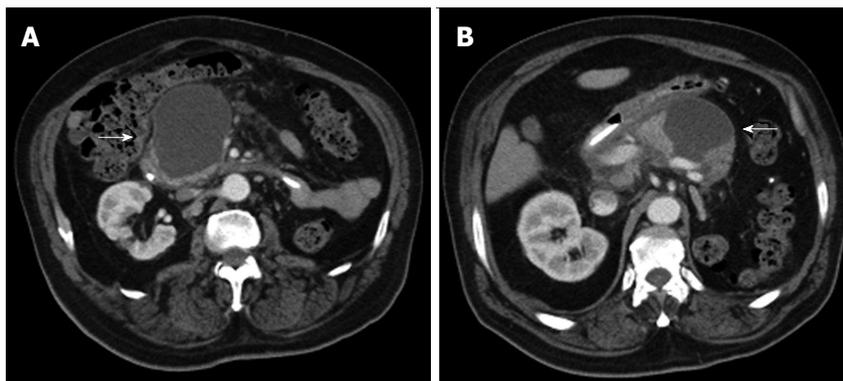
Axial contrast enhanced multidetector computed tomography images (A, B) reveal a homogeneously hypodense intraparenchymal fluid collection of the pancreas without any non-liquefied material in it, encapsulated completely by a thin slightly hyperdense layer (arrows). These findings are compatible with a pseudocyst in a patient with a clinical history of pancreatitis.
